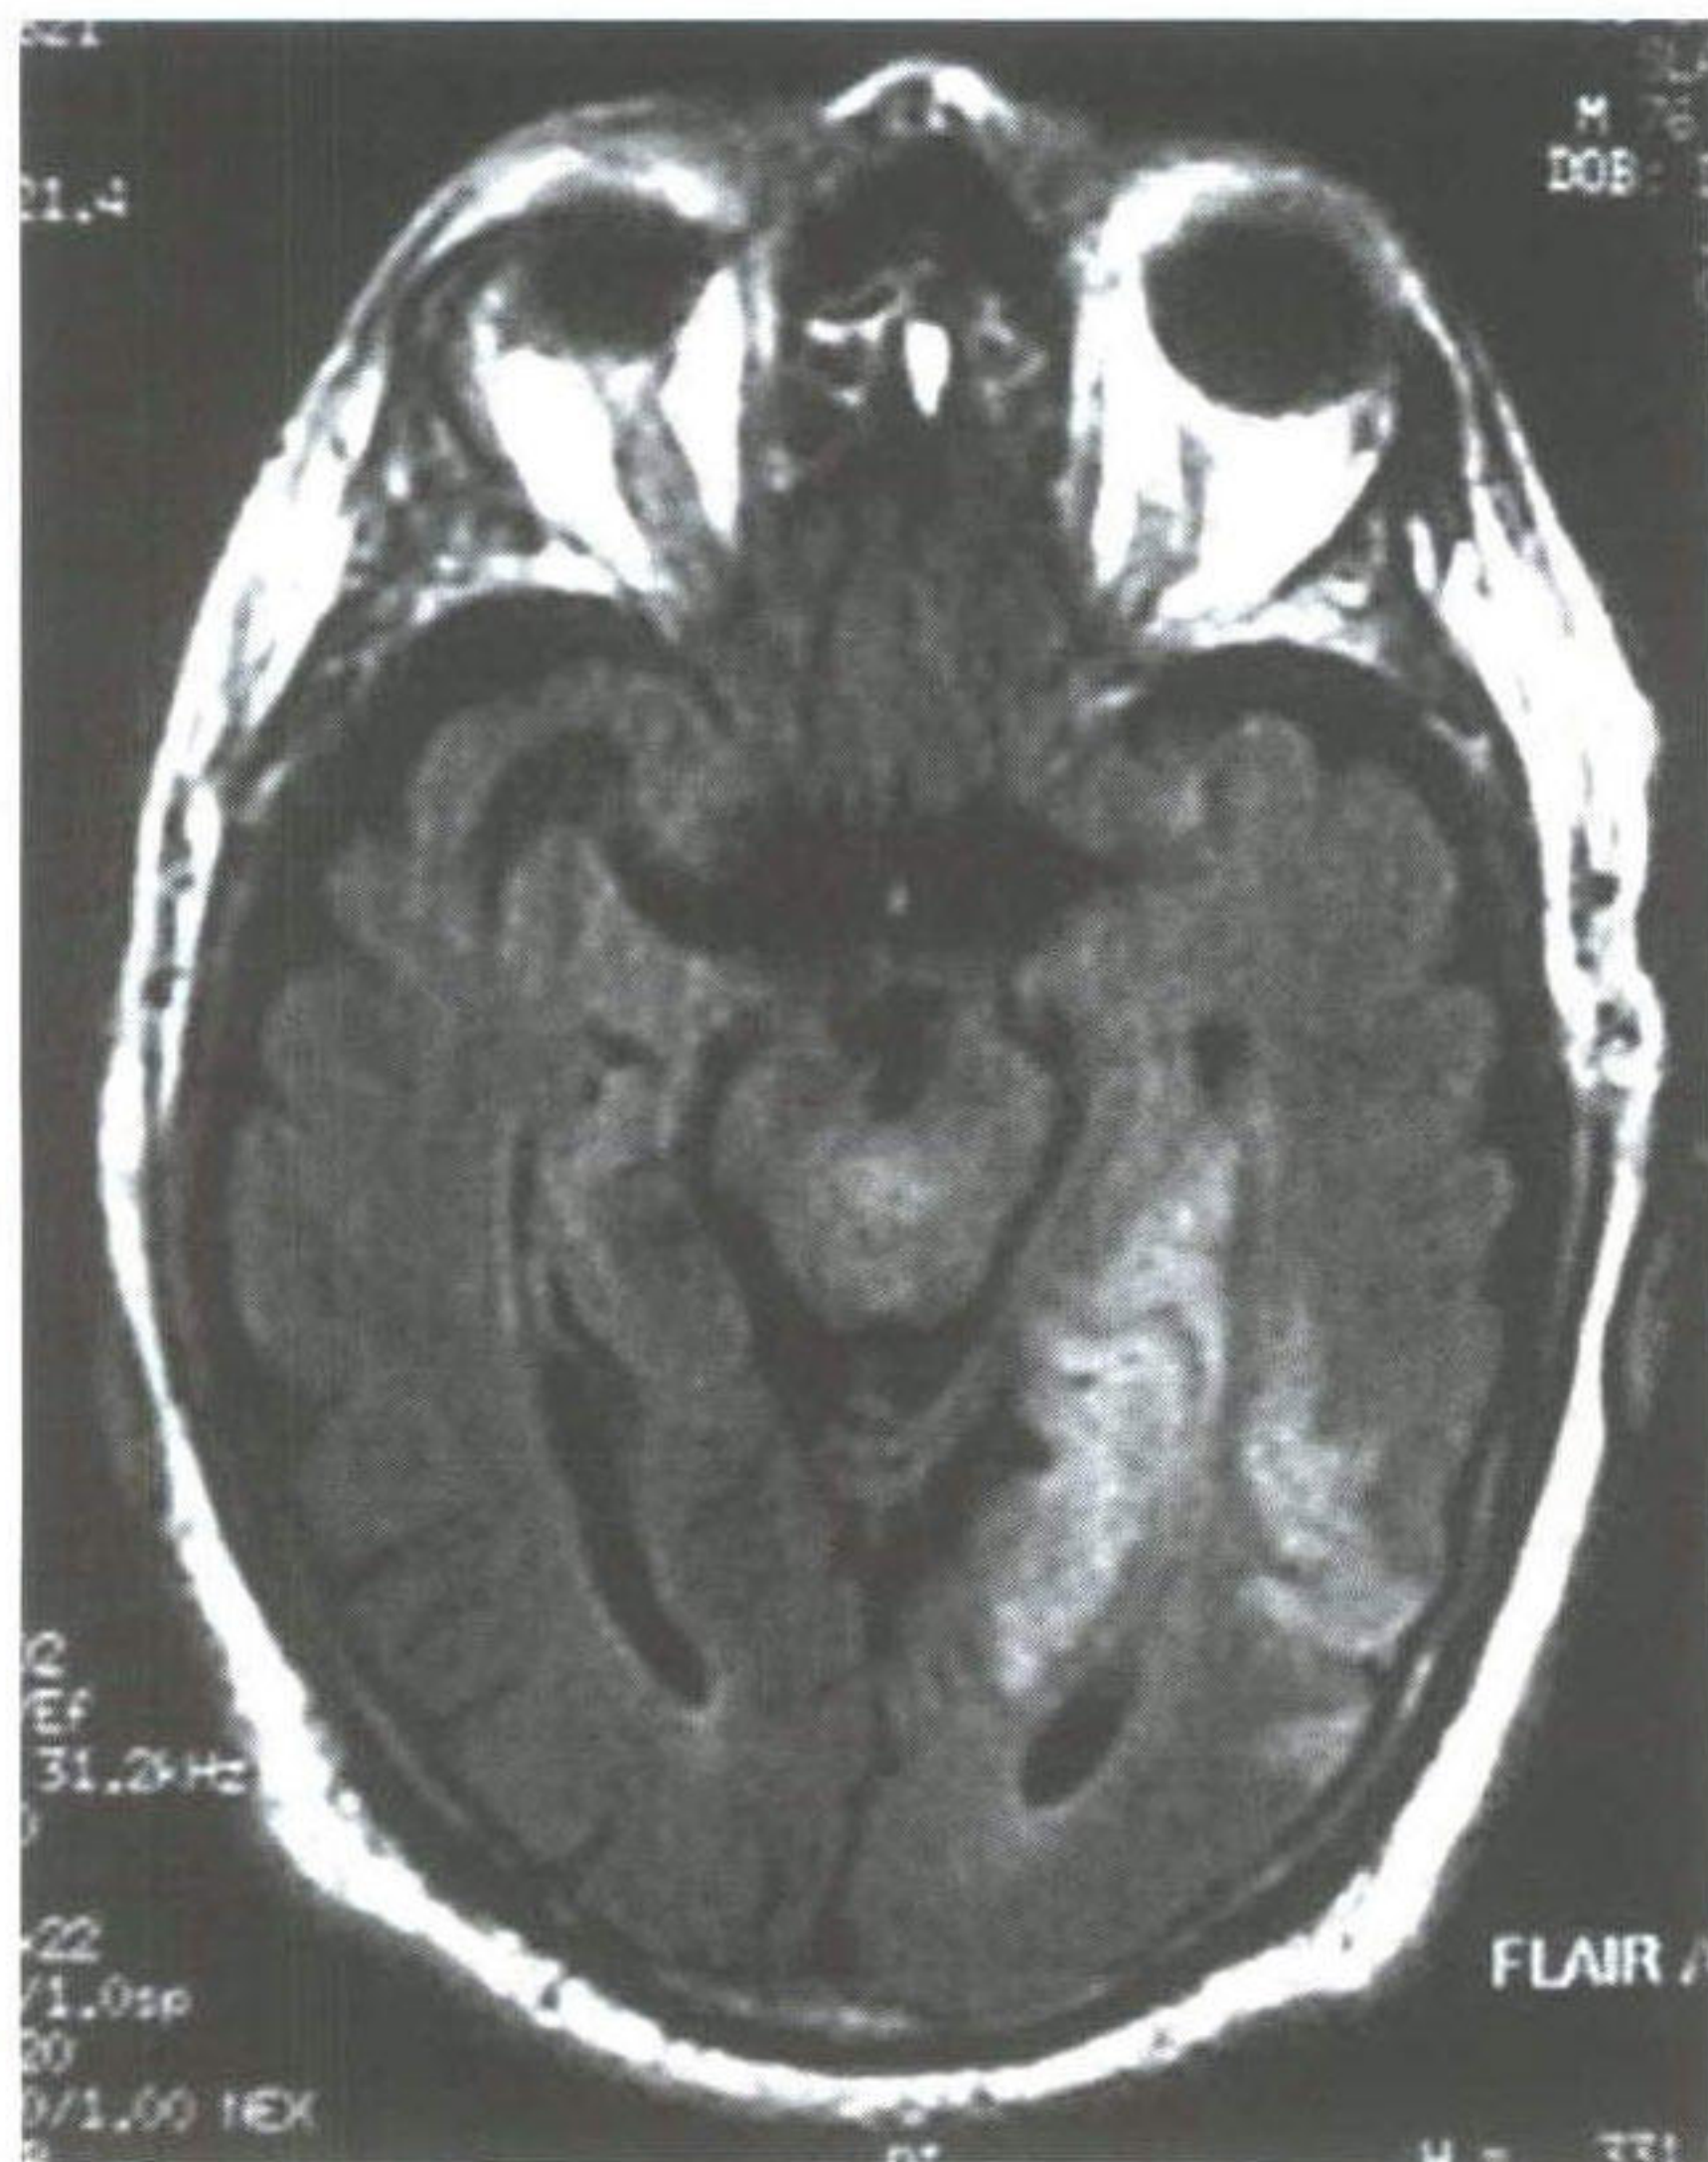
MRI scan for JS taken 1 day after the stroke.
